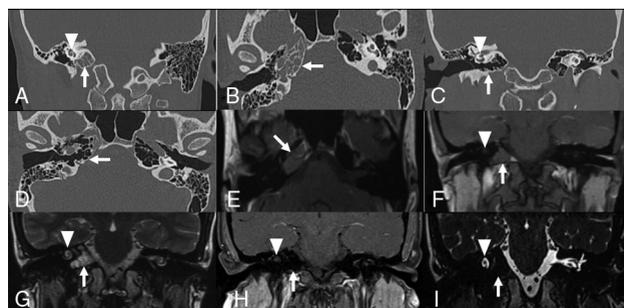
The preoperative views of the effusion on coronal (A) and axial (B) sectioned temporal CT. The postoperative views of the drained cells on coronal (C) and axial (D) sectioned temporal CT. The view of petrous apex effusion on T1-weighted images with contrast of MRI (E). The preoperative views of the effusion on coronal sectioned T1 (F) and T2 (G) weighed MRI. The postoperative views of the drained cells on coronal sectioned T1 (H) and T2 (I) weighed MRI. White arrowhead: cochlea, white arrow: petrous apex cells.
